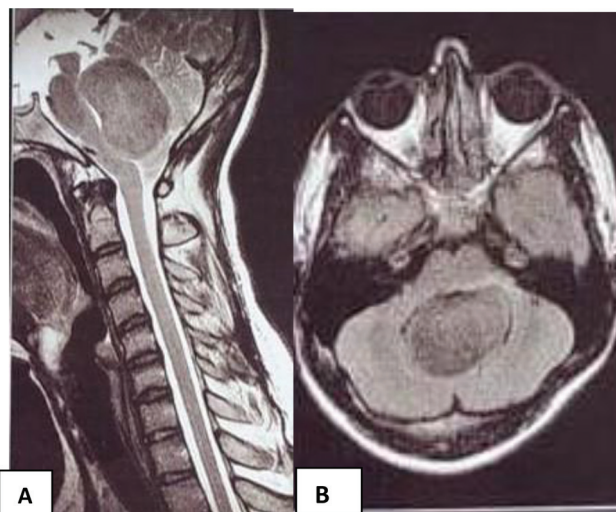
(A, B) Magnetic resonance imaging revealed a lobulated ovoid space-occupying lesion in the region of fourth ventricle measuring approximately 4.6 cm × 3.5 cm causing moderate obstructive hydrocephalus. No periventricular ooze of cerebrospinal fluid was noted. Moderate compression over pons and medulla with caudal protrusion of cerebellar tonsils by 10 mm secondary to mass effect in posterior fossa was noted.
